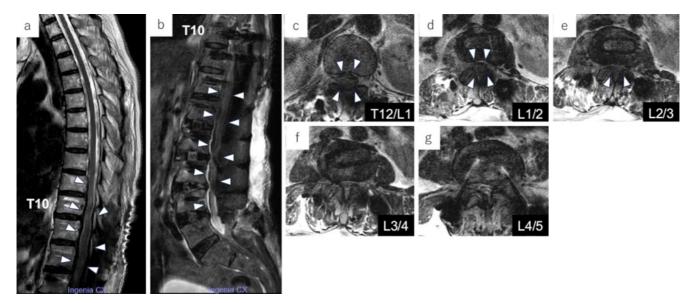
Magnetic resonance images after the first operation.
